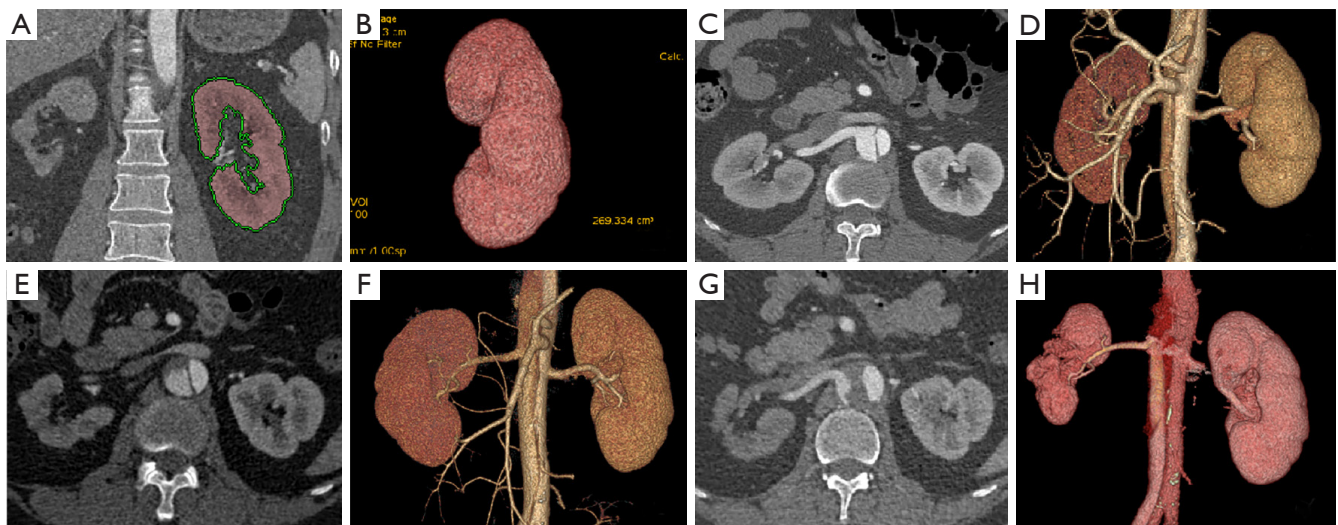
CT images of renal and kidney in a TBAD patient. (A,B) Show that a kidney was labeled in the postprocessing workstation, and kidney volume was semiautomatically calculated. (C-H) Show the CT images of a patient before TEVAR, 3 days after TEVAR, and 2 years and 6 months after TEVAR, respectively. (C,D) Show the preoperative CT axial and VR images. The right renal artery belonged to type 2 originating from the aortic false lumen; both kidneys were of approximately equal volume (right kidney volume: 238.42 mL; left kidney volume: 250.97 mL). (E,F) The axial CT and VR images showing partial thrombosis in the abdominal aortic false lumen; there is a small difference in volume between the 2 kidneys (right kidney volume: 200.37 mL; left kidney volume: 237.53 mL). (G,H) The axial CT and VR images showing the enlarged thrombus and right renal atrophy (right renal volume: 107.55 mL; left renal volume: 230.64 mL). CT, computed tomography; TBAD, type B aortic dissection; TEVAR, thoracic endovascular aortic repair; VR, volume rendering.
